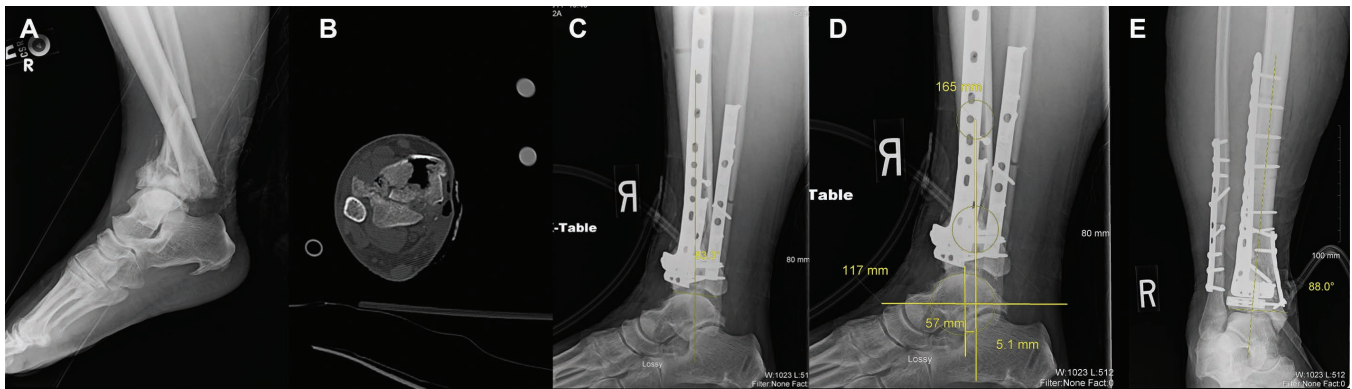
(A) An injured right ankle lateral radiograph showing a pilon fracture with anterior impaction and comminution; (B) an axial CT scan showing anterior pilon comminution; (C) an immediate postoperative lateral radiograph of the right ankle showing anterolateral primary plate and accessory anterior plate with ADTA of 83.3°; (D) an immediate postoperative lateral radiograph of the right ankle showing LTS of -5.1mm; (E) an immediate postoperative anteroposterior (AP) radiograph of the right ankle showing anterolateral primary plate with accessory anterior and medial plates, bone graft substitute, and an LDTA of 88°.
